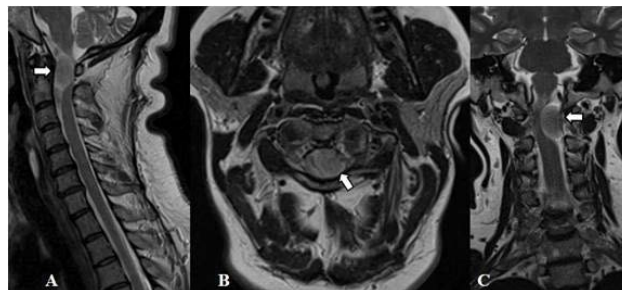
T2-weighted MRI in a patient with left ventro-lateral foramen magnum meningioma extending to C1-C2 level in sagittal, axial and coronal views (A-C).
